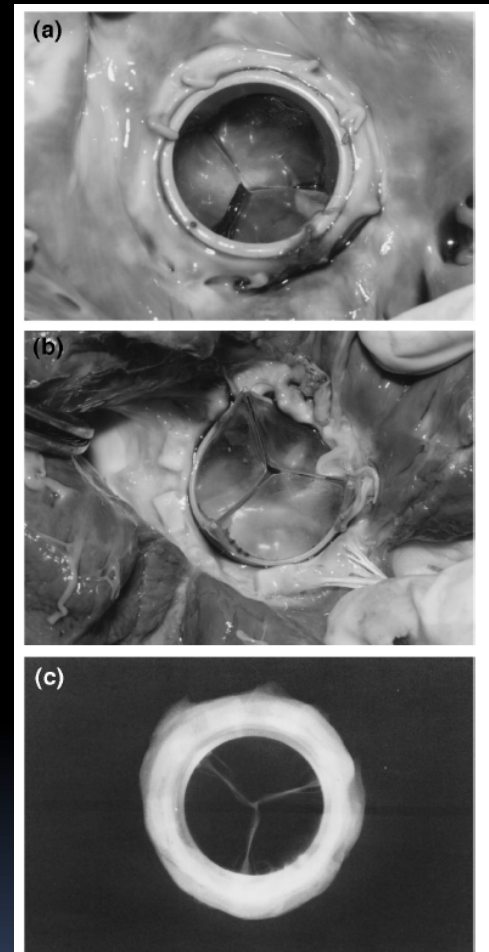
Explant polyurethane valve viewed in situ immediately prior to explant. (a) Inflow surface; (b) outflow surface; (c) radiograph of explant polyurethane valve.
